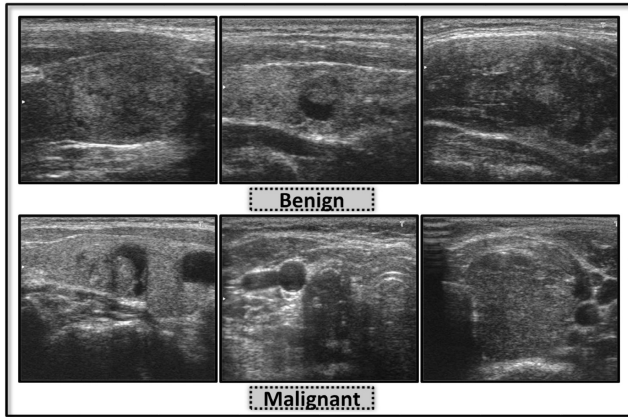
Visual Representation of Tumor Classification for Ultrasound Images in the Dataset.
